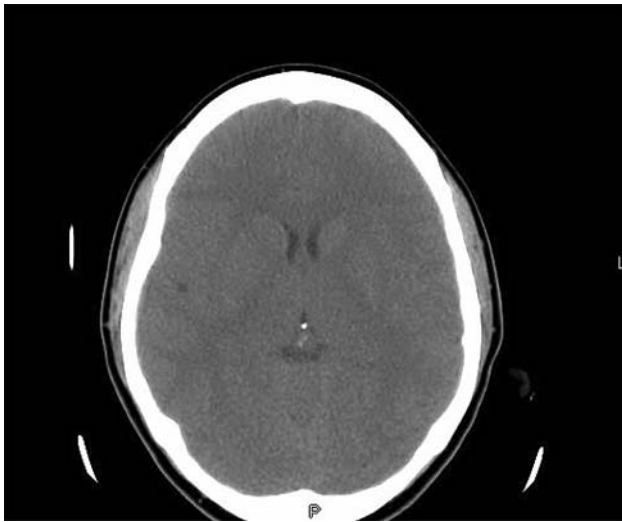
CT scan of brain on admission showing cerebral edema
